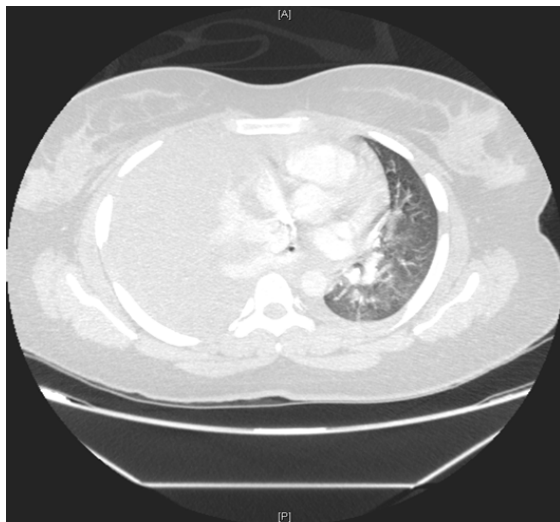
CT chest showing a massive right side pleural effusion associated with collapse of the right lung and mediastinal shift.
